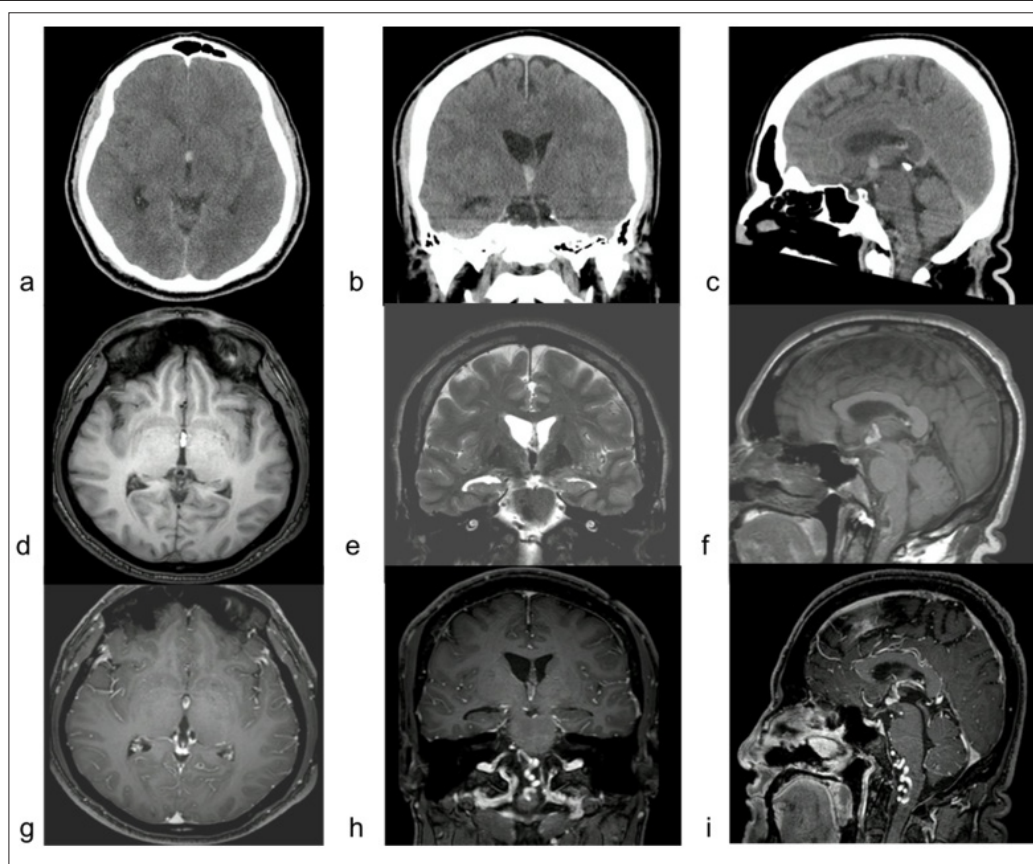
Brain CT scan and MRI simple and with gadolinium
